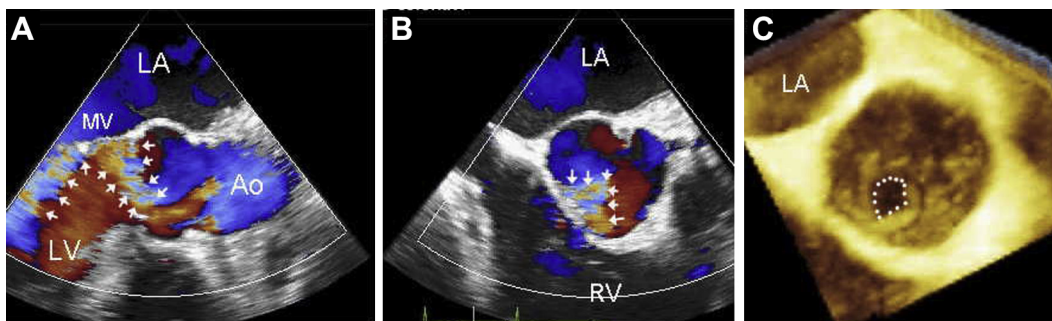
Patient with aortic regurgitation with Austin Flint diastolic murmur. (A) long-axis view of transesophageal echocardiography (TEE) image shows backflow of blood from the aorta presses on the anterior leaflet of the mitral valve (multiple arrows), producing functional mitral valve stenosis; (B) the corresponding view of short axis demonstrates the regurgitant orifice on right and non-coronary cuspid (arrow); and (C) three-dimensional TEE delineates the regurgitant orifice (circle). Ao = aorta; LA = left atrium; MV = mitral valve; RV = right ventricle.
